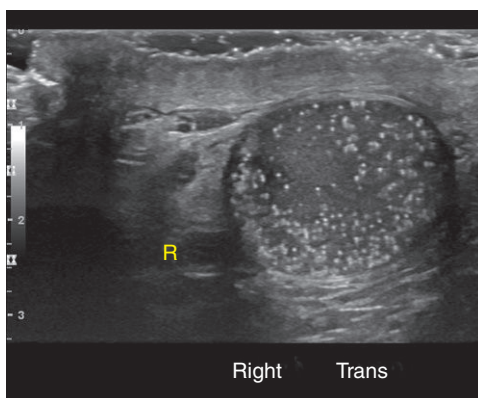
Ultrasound of the right (R) testis shows multiple echogenic foci scattered throughout the testis.
